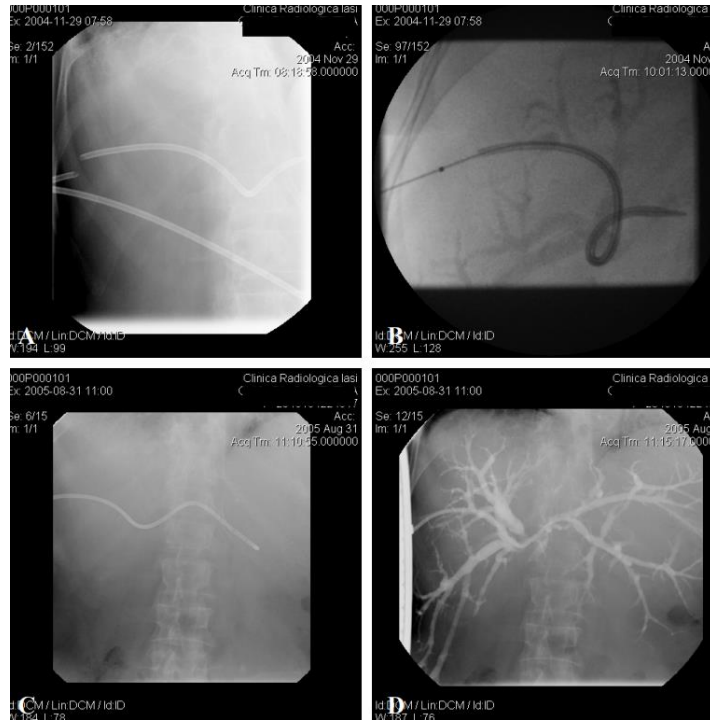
Fracture and replacement of the drainage catheter: A. Right upper quadrant X-ray: Catheter fracture. B. Extraction with a balloon catheter. C. catheter replacement; D. Cholangiography to check the position of the catheter.
